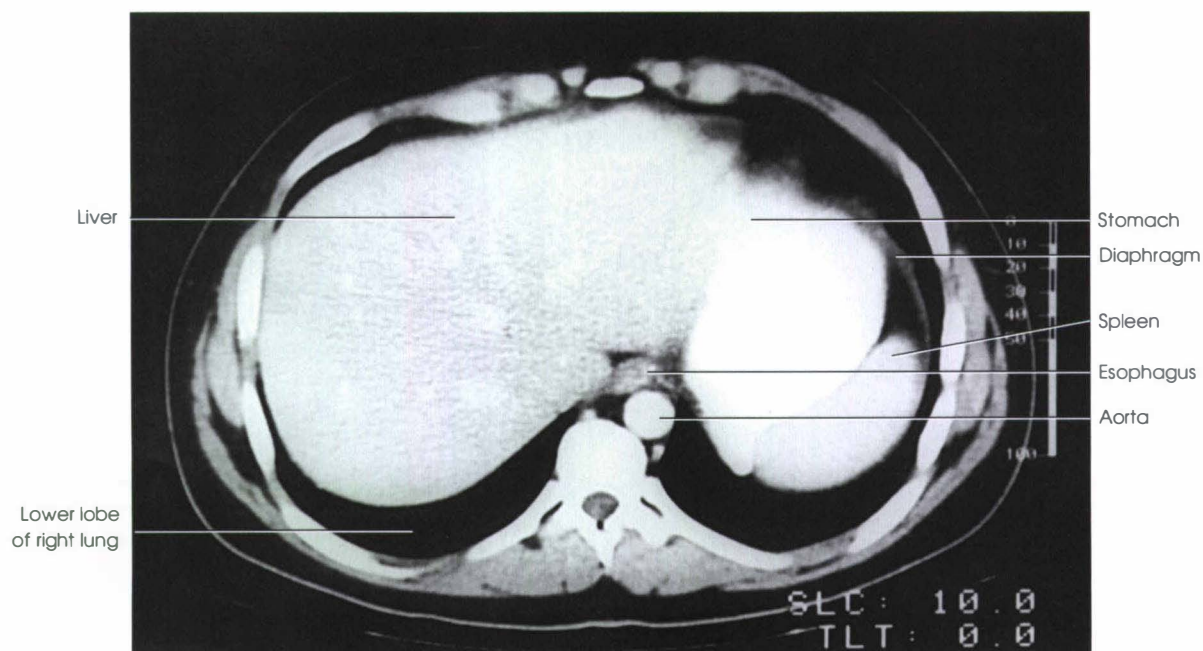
CT image corresponding to Fig. 27-28.
